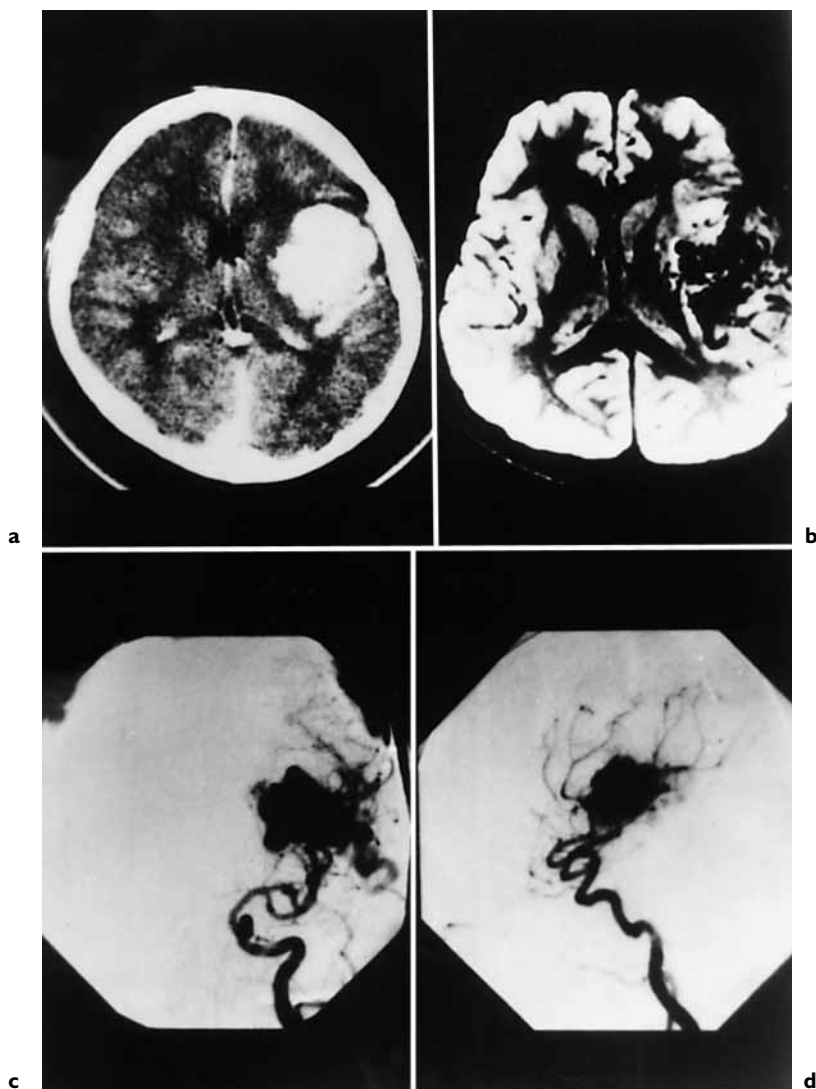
a, b CT scan and MRI revealed a large hematoma with on AVM in the left fronto-temporal. c, d Four-vessel angiography disclosed an AVM at the location of the hematoma.
